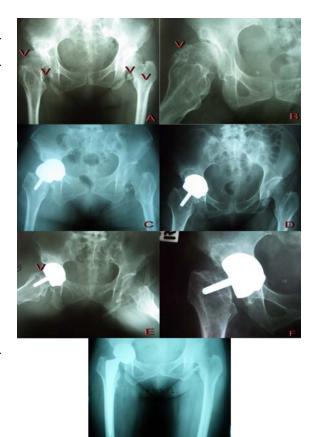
A, B Thai 43-year old female develop secondary osteoarthritis right hip from DDH Crowe II, underlying familial multiple exostosis especially at anterosuperior head neck junction of right femur. In C, Immediate post-op X-ray before end of anesthetic effect show subluxation from inadequate soft tissue tension due to medializatoin of metal cup and uncorrectable lateral head offset. Next day in D, after muscle tone came back, head was reduced, however broken Shenton's line still occur. In E, Anterosuperior cancellous expose because removal exostosis and very thin cortex at this area. In F, she was advice to protect weight on her right leg for 3 months, a few days after start weight on left leg, fracture neck happened. Successfully conversion to metal-on-metal total hip arthroplasty was performed. She was then went back to work with normal quality of life
